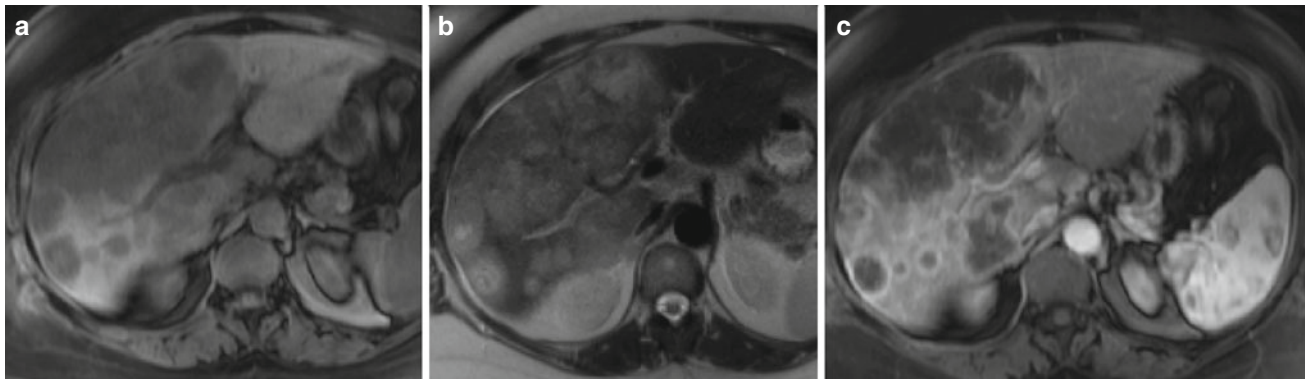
a–b T1- and T2-weighted images show multiple hepatic masses throughout the liver, with a more confluent area of tumor within the inferior right hepatic lobe consistent with metastatic cholangiocarcinoma. These lesions demonstrate rim enhancement on c arterial phase
